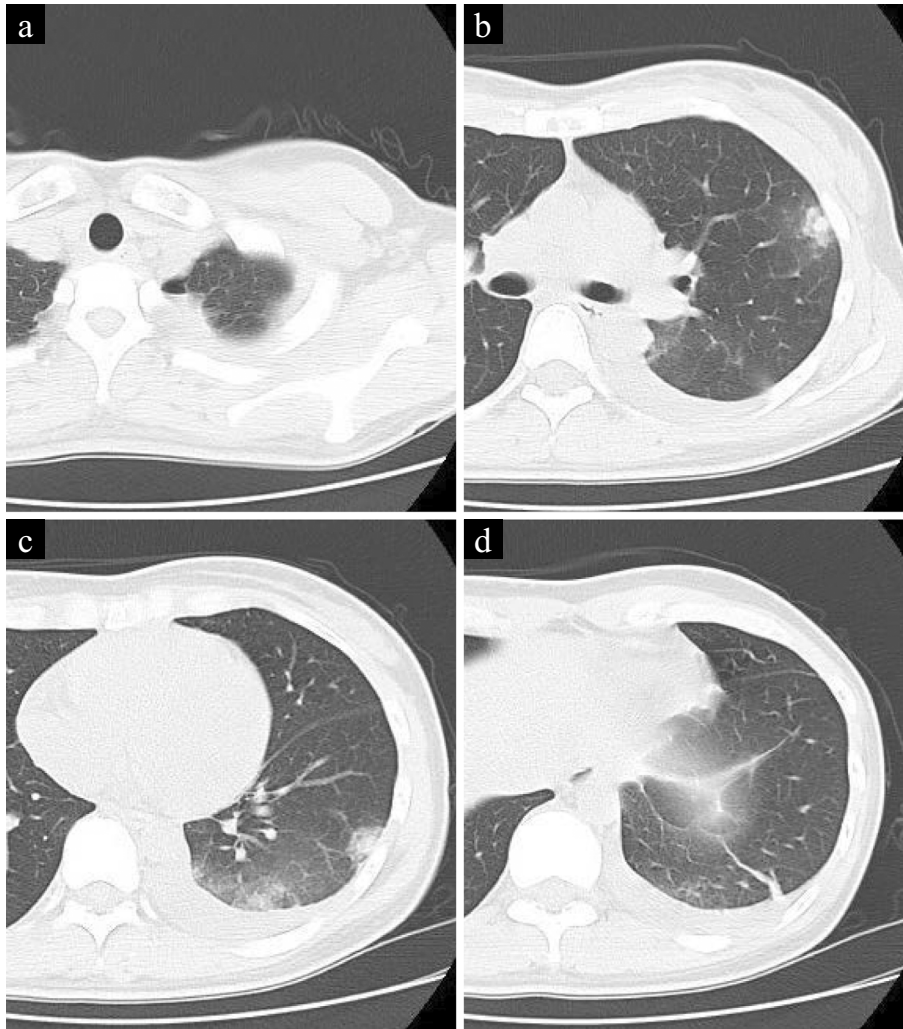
Chest CT at admission. (a) Pneumothorax and pleural effusion are observed in the left lung field. (b, c) Pulmonary infiltrates are observed in left upper and lower lobe. (d) Linear opacity is also observed in the left lower lobe.
